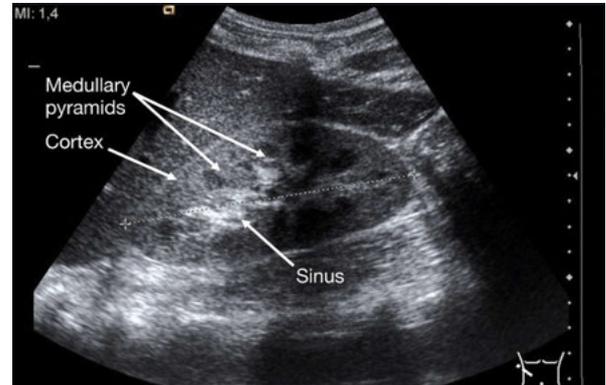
Ultrasound of the kidney. The cortex and medullary pyramids can be seen, and centrally the more echogenic sinus, which contains the collecting system, vessels, and lymphatic structures.
